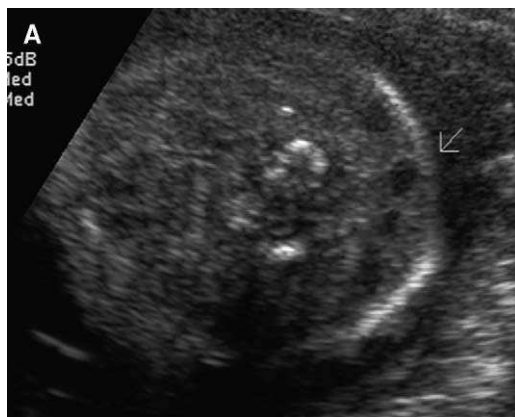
(A) Sonogram and (B) MR image of fetus with nuchal thickening. Note the soft tissue with septations behind the neck seen on the sonogram (arrow). On MR imaging, the nuchal area has a more simple cystic appearance because of the high fluid content.
